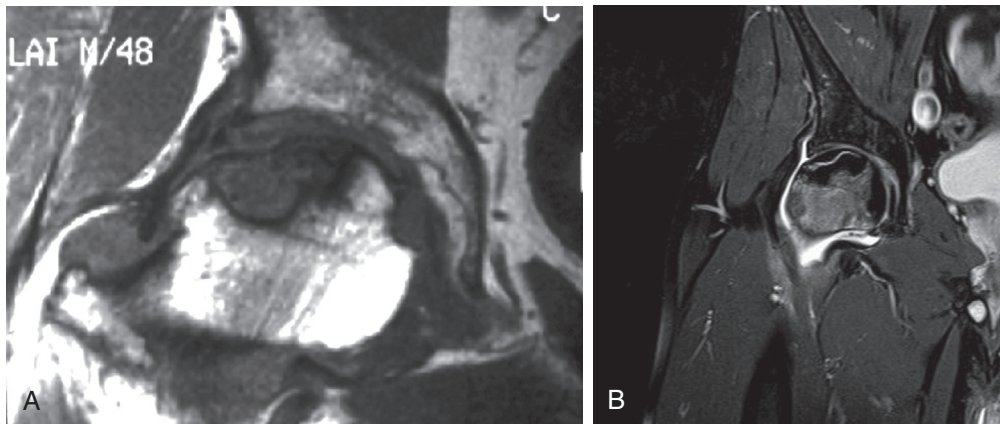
A, On a T1-weighted coronal MRI of the left hip, the osteonecrotic segment in the subchondral portion of the femoral head shows low signal intensity. B, On a T2-weighted coronal image, the necrotic bone exhibits high signal intensity, surrounded by a sclerotic low signal rim. The low signal intensity rim surrounds a high signal intensity rim, representing the double-line sign (see also [Figure 103-9](#)). Note that the signal intensity of the necrotic area is heterogeneous in both the T1- and T2-weighted sequences.
